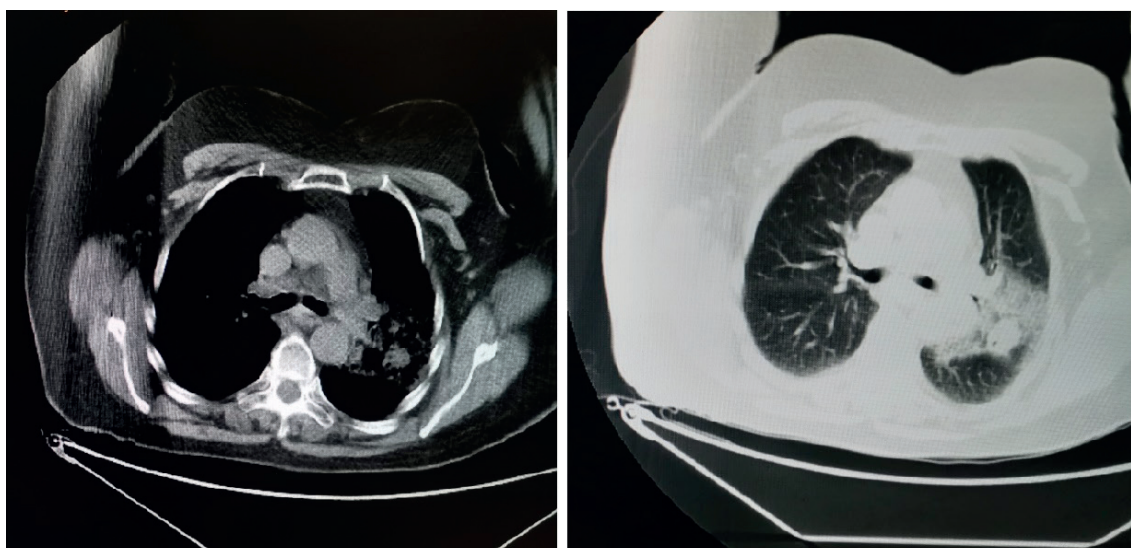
Initial chest CT scan showing dense airspace opacities in the left upper lobe with a 2.7 cm rounded density in left upper lobe.
